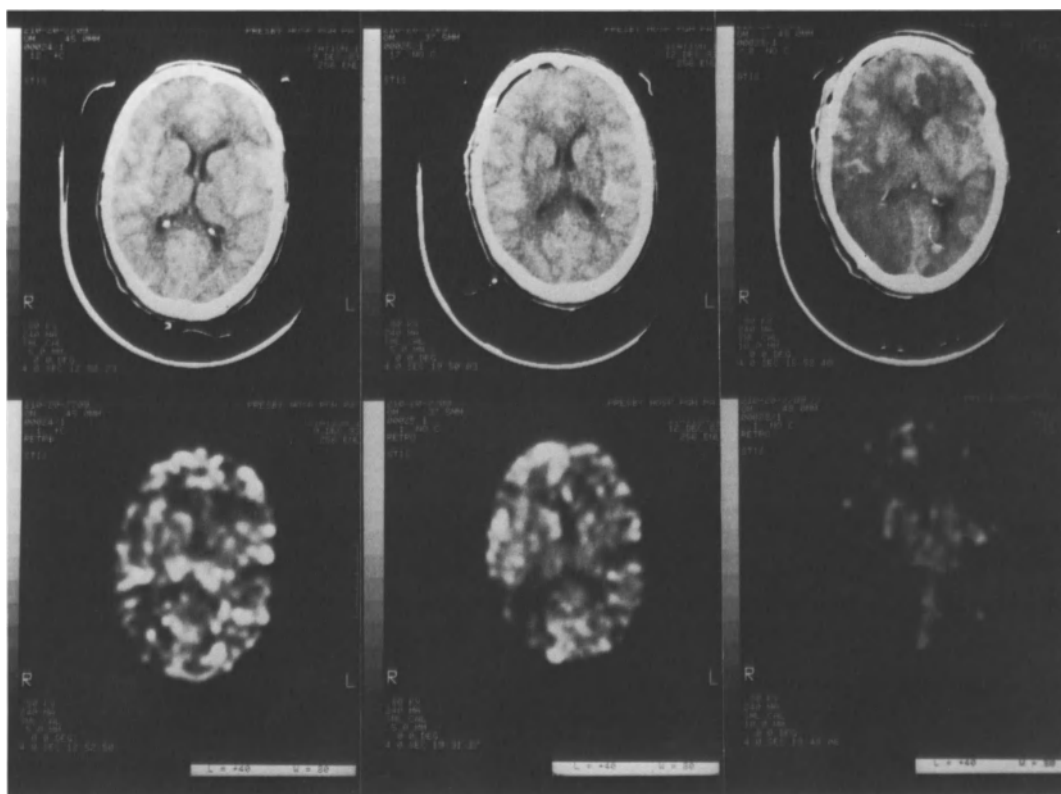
This series of CT/CBF studies was obtained in a 50-year-old woman who survived subarachnoid hemorrhage (SAH) due to an anterior communicating aneurysm. The initial study (CT above left and flow study below left) was obtained five days post SAH when the patient was neurologically intact. Note reduced right posterior parietal flows. The second study (center CT above and CBF map below) was obtained the evening following surgical treatment of the aneurysm when the patient was slow to awaken. Note hyperemia in area of surgery and markedly reduced flows in right posterior parietal region. The third study was obtained the day following surgery when the patient was comatose. Note the transition of the lowest flow regions on the prior study to CT-defined infarctions. Also note the near absence of any cortical CBF. Patient progressed to brain death. The CBF gray scale was 0–80 cm<sup>3</sup>/100 g/min for these studies
